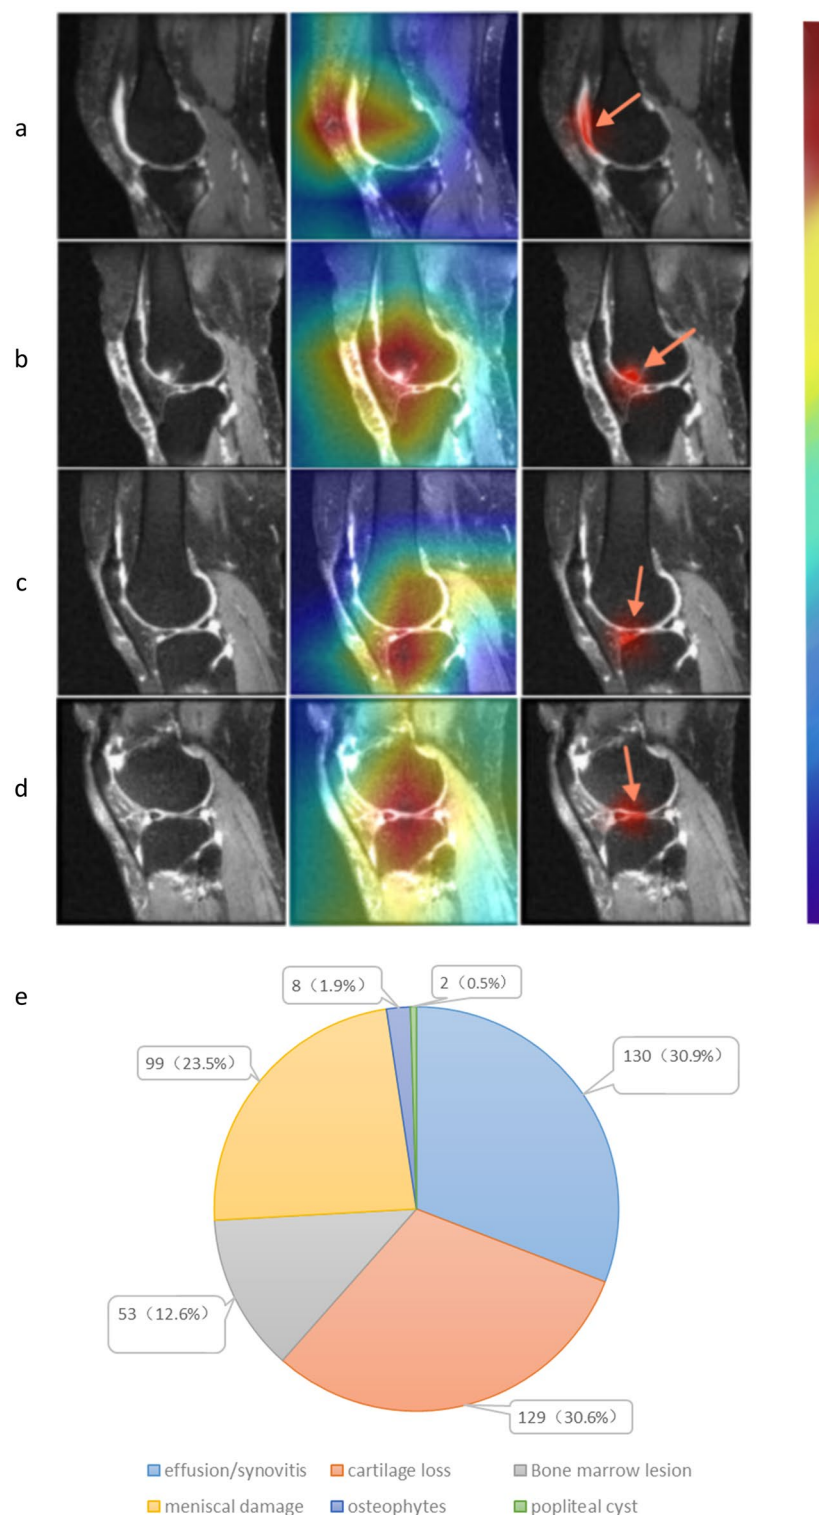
The left column showed the original sagittal MRI, while the middle column showed the CAMs of the selected subjects. The right column showed the specific lesion identified by the radiologist. In detail, effusion/synovitis (a), meniscus damage (b), bone marrow lesions (c), and cartilage loss (d) were the lesions present within the CAMs. (e) Displays the corresponding number of each lesion in these cases.
